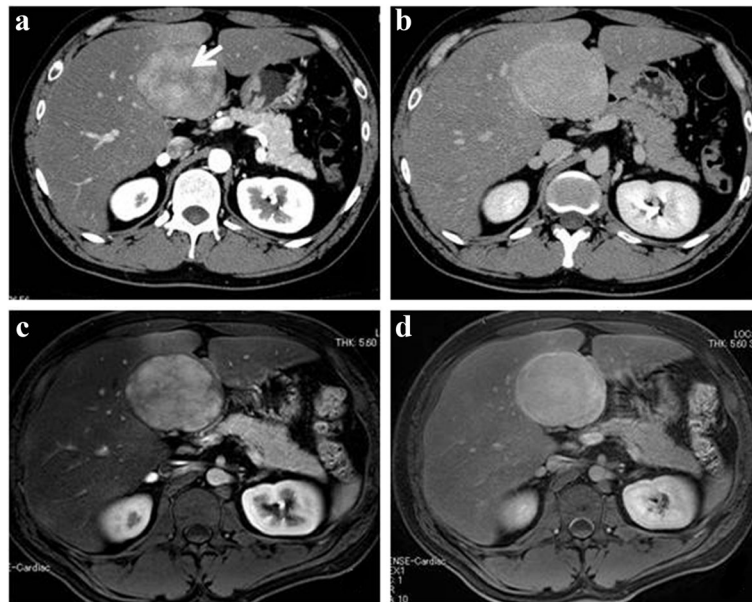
Diagnostic imaging findings upon first admission. Dynamic abdominal CT imaging reveals an 8-cm mass projecting from the liver. Contrast enhancement is mainly on the border, and it is observed in the early phase (a) until the late phase (b). In the early phase, a low-density area in the tumor is considered as a central stellate scar (*arrow*). Dynamic abdominal MRI shows contrast enhancement in the early phase (c) until the hepatobiliary phase (d)
